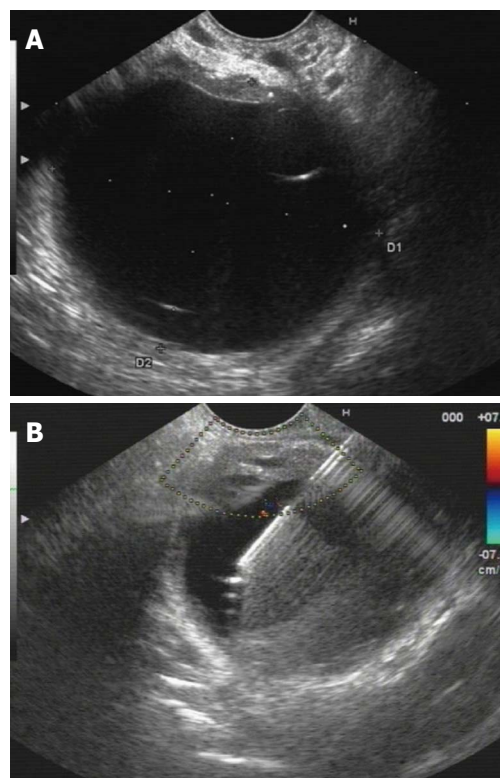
Endoscopic ultrasound. A: Endoscopic ultrasound view of the lesion; B: Color Doppler ultrasonography was applied to identify the regional vasculature and used during endoscopic ultrasound-guided puncture.
